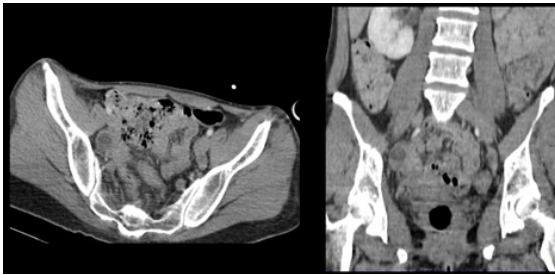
Abdominal-pelvic CT.
